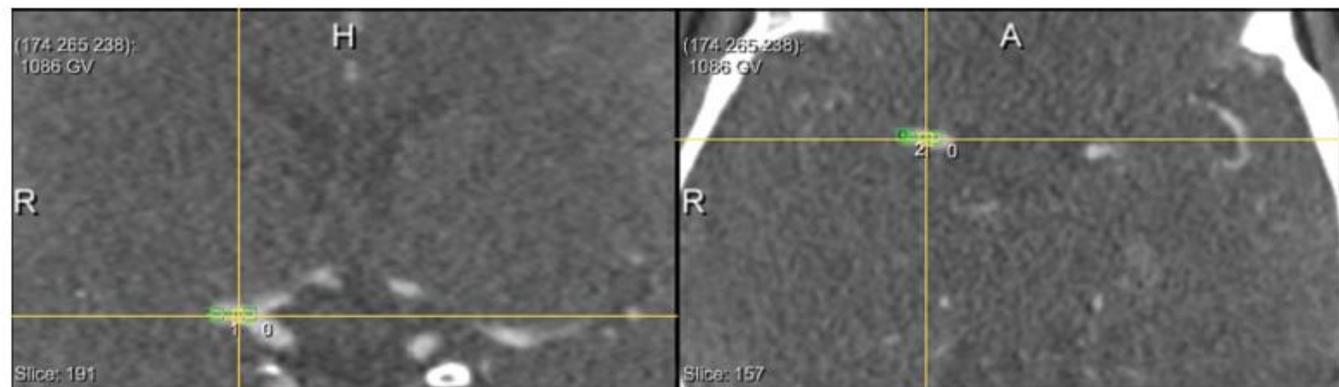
Distance from the ICA-T to the thrombus. Placement of seed points in the vessel from the ICA-T to the thrombus by the observer. Subsequently, the software determined the centerline through the vessel, which represents the distance from the ICA-T to the thrombus. Left: coronal view CTA. Right: axial view CTA.
